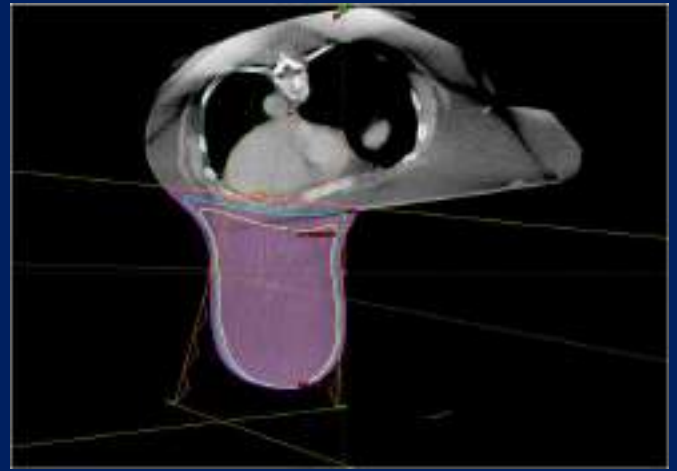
Planning CT image, showing dose distribution and beam angles
